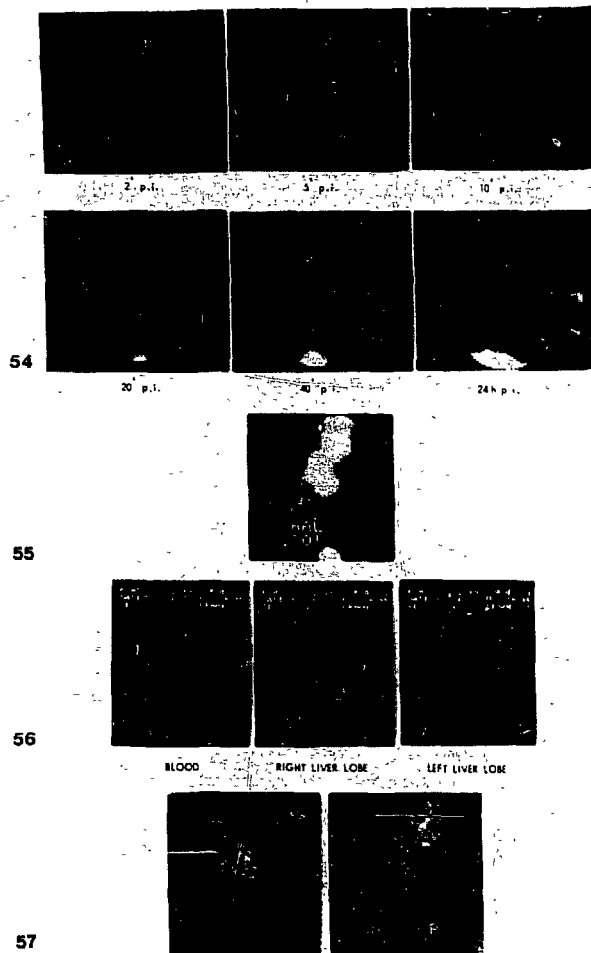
54-57 Cholescintigraphy in a patient with carcinoma of the gallbladder and multiple liver metastases.
